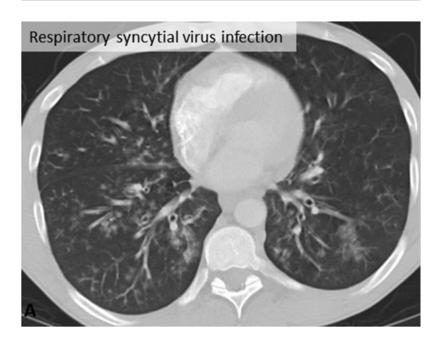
Atypical CT imaging features for COVID-19. Axial
